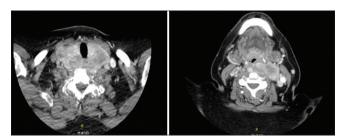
Computed tomography neck with contrast: Large longitudinal heterogeneously enhancing thyroid mass, spanning the distance from C3 to T5, extending superiorly the level of hypopharynx, posteriorly with retropharyngeal extension and inferiorly through the thoracic outlet into the retrosternal area
